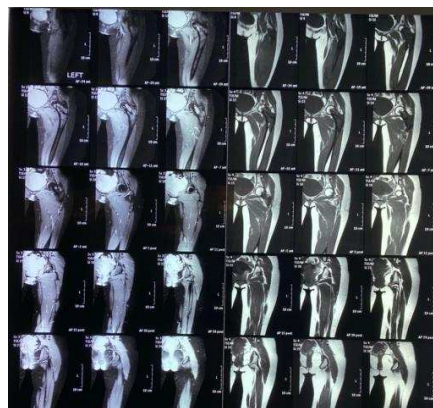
MRI on coronal section without contrast
